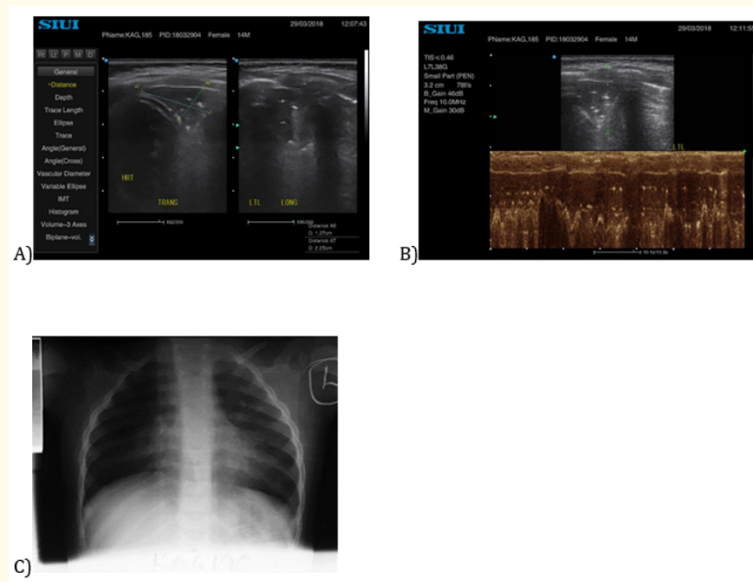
A 14 months old admitted with pneumonia. A) left paracardiac wedge shaped shred sign with air bronchogram (echogenic foci). B) M-Mode showing dynamic motion of the air bronchograms. C) An AP radiograph showing a radio-opacity forming a positive silhouette sign with the left cardiac border.
